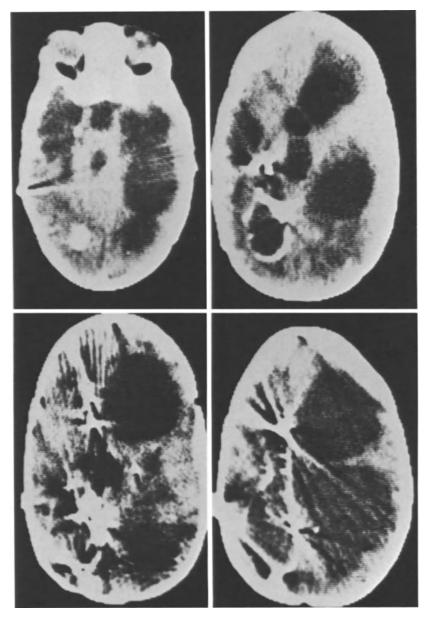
Polycystic transformation of hydrocephalus, late phase in case 126. Progressive polycystic transformation especially on the right side, after newly inserted left sided shunt (CT Jan. 24, 1979)
